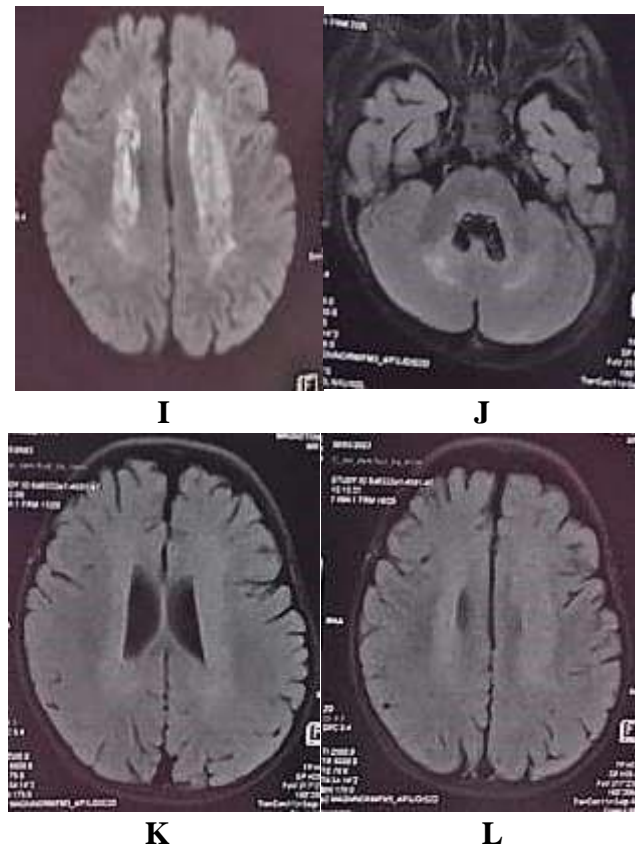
(A), (B) and (C) axial CT images show hypodense areas at both cerebellar, corona radiata and centrum semi oval regions. (D), (E) and (F) axial T2W MRI images, (G), (H) and (I) axial DWIs, (J), (K) and (L) axial FLAR; showing hyper signal intensities, and restricted diffusion at these regions.
